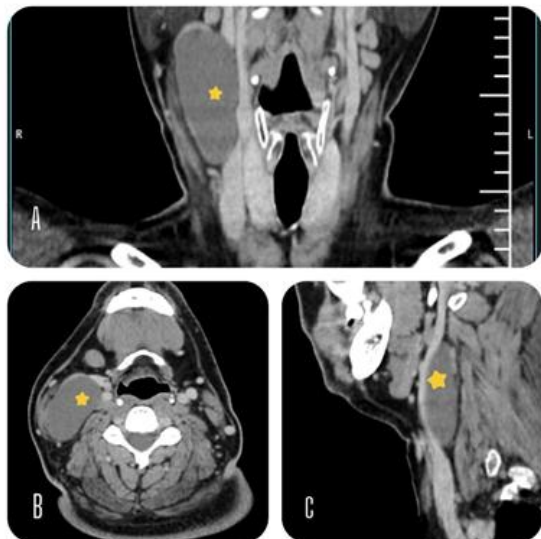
Computed Tomography of the neck depicting the branchial cyst in A. Sagittal section B. Axial section C. Coronal section
